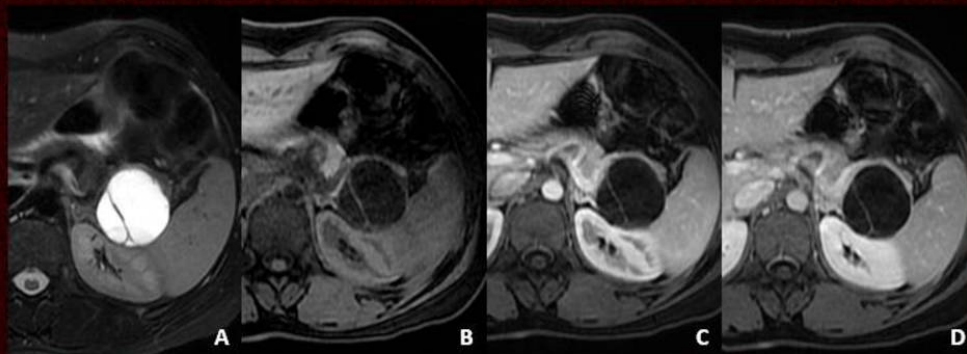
MR findings of mucinous cystadenoma. T2-weighted (A) and T1-weighted fat-suppressed dynamic study before (B) and after (C) IV administration of Gadolinium depict a cystic mass in the pancreatic tail. There are few non-enhancing septations. No mural nodules were found.
